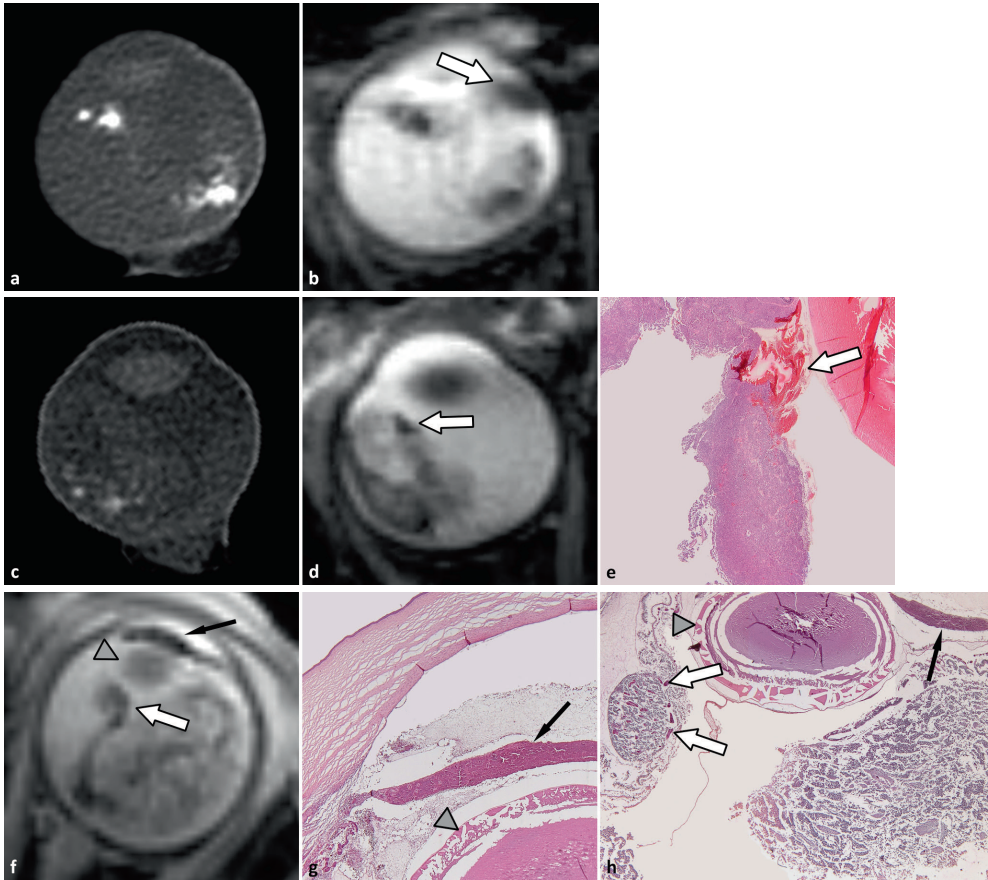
Examples of additional signal intensity voids on T2*-weighted MR images without correspondence with ex-vivo high resolution CT.
